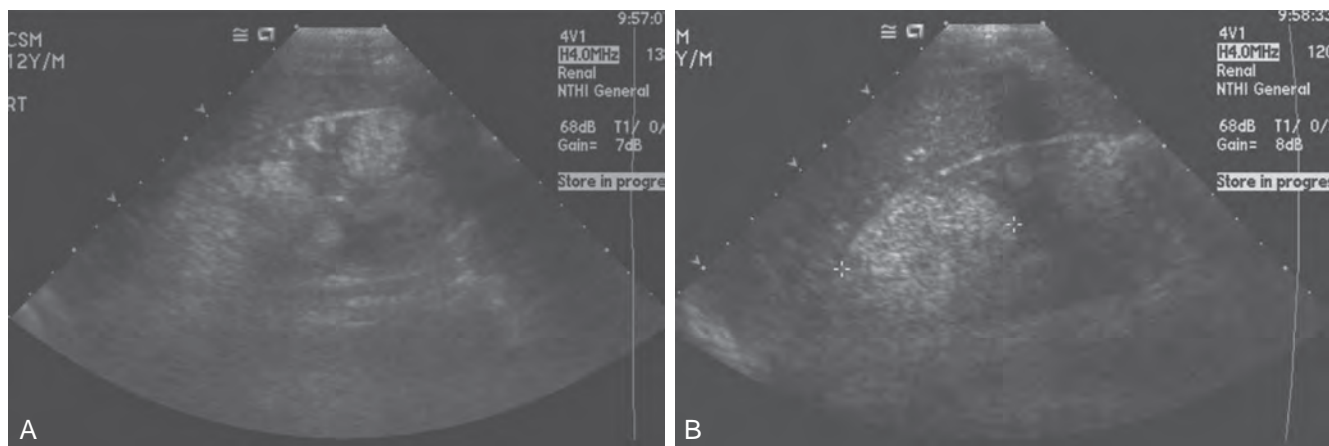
A and B, Renal ultrasonogram of 13-year-old patient with tuberous sclerosis. Multiple hyperechoic lesions of varying size are visible, consistent with angiomyolipomas. (Courtesy Marta Hernanz-Schulman, MD.)
